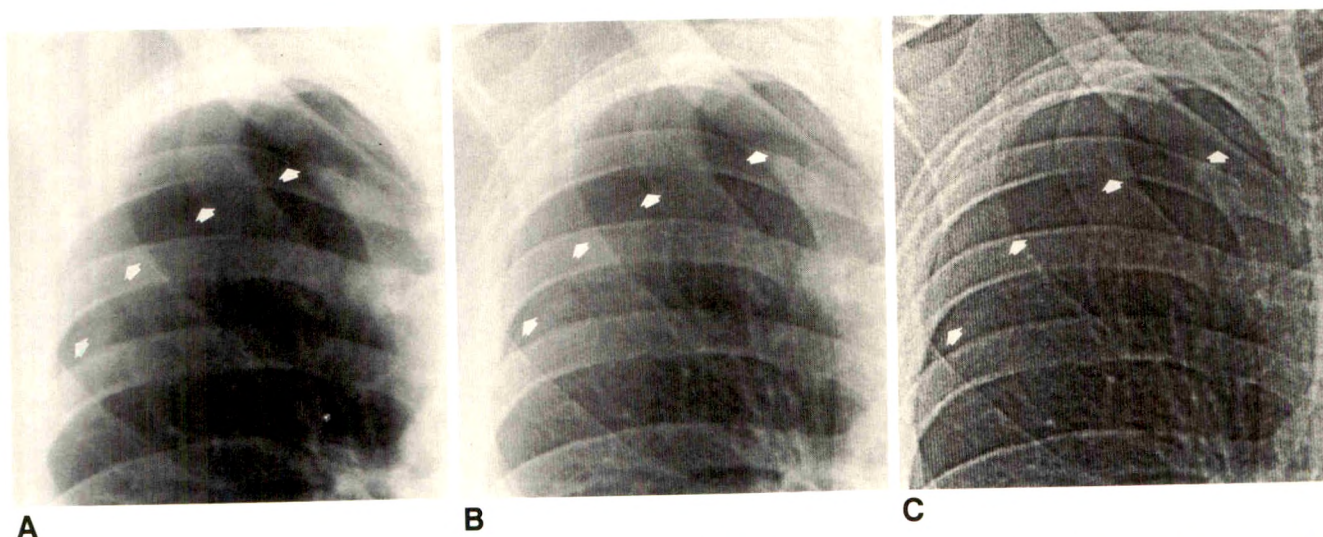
Conventional screen-film (A), computed (B), and frequency-modified computed (C) radiographs show a right apical pneumothorax (arrows).
